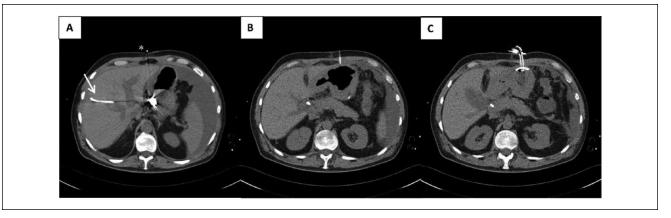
Fifty-three-year-old patient with a history of partial gastrectomy and gastroenterostomy because of gastric cancer was referred for decompression percutaneous gastrostomy. The patient presented with peritoneal carcinosis, and no adequate transillumination could be obtained during previous esophagogastroduodenoscopy. (A) Gastroscope is shown inside the stomach; note external biliary drainage tube because of obstructed bile duct (arrow) and external wire guide for orientation (asterisk). (B) Computed tomography–guided puncture of the stomach. (C) Image after placement of the tube (pull-through type) inside the stomach.
